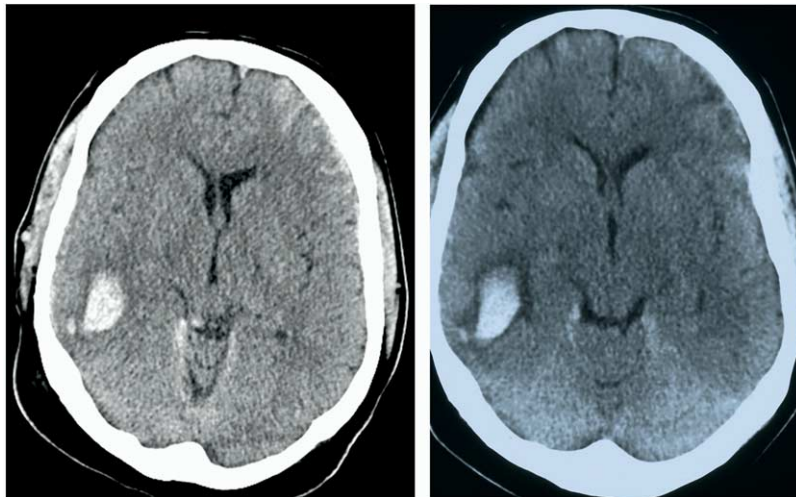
CT scans of a hemorrhagic contusion of a severely head-injured adult. At 6 h after TBI (left) the lesion is hyperdense only demarcating the hemorrhagic core. By 36 h, the lesion is surrounded by a perifocal halo (area of low density), consisting of both vasogenic and predominantly cytotoxic brain edema.
